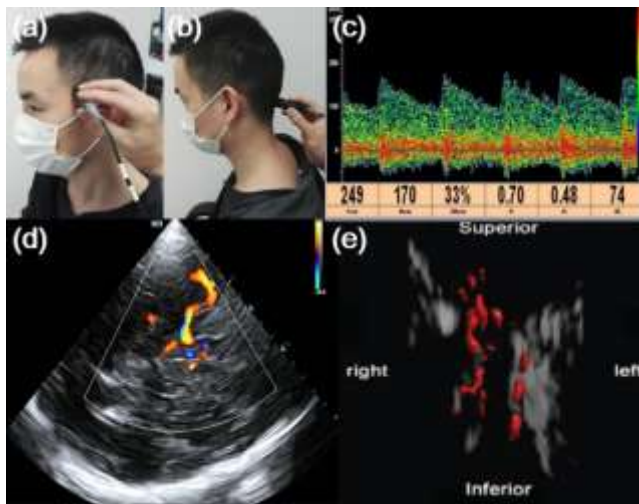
Transcranial ultrasound imaging method and clinical images. The acquisition position of a TCD probe through (a) temporal window and (b) occipital window. (c) Pulsed wave Doppler imaging in the human brain. The images are provided by Delica. (d) Color Doppler image of the blood flow of the middle cerebral artery. The image is provided by Mindray. (e) The 3D cerebral flow ultrasound imaging. The image is from [45].
